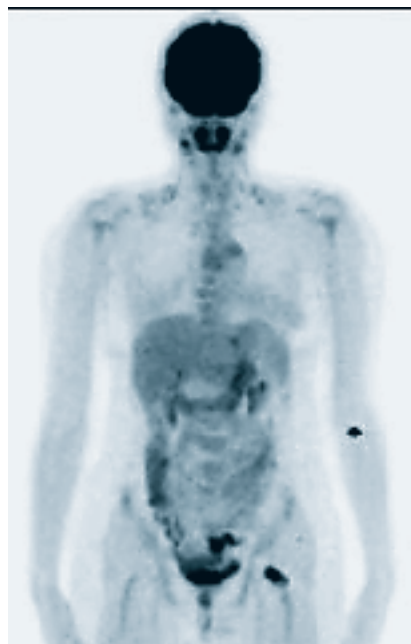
Maximum small intensity projection (MIP) image shows a focal area of intense ^{18}F -FDG uptake mainly in the neck region of the left femur. Average and small maximum standard uptake values were 10.3 and 11.55 respectively. Note is made of low grade uptake in the rectovesical area and the right iliac region corresponding to the residual disease. Focal uptake in the left forearm corresponds to injection site contamination.
